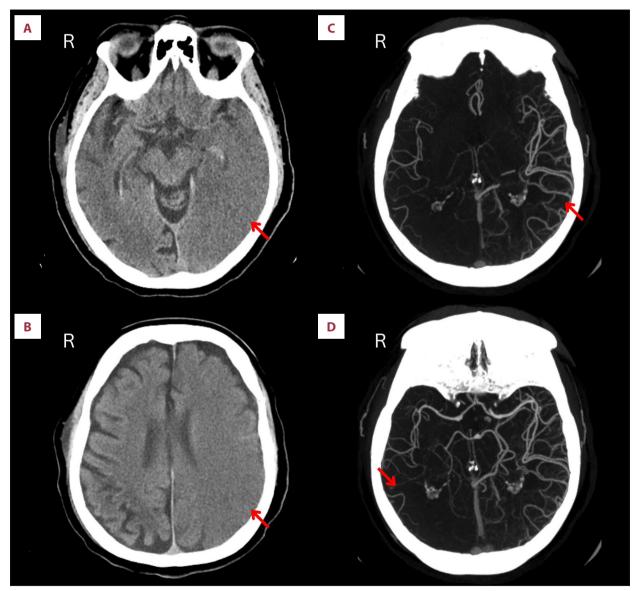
(A, B) Axial computed tomography brain scan showing mild hypodense acute ischemia zone throughout the left cerebral hemisphere, except the basal nuclei. (C, D) Angiography maximum intensity projection revealing more pronounced vasodilated cortical branches in the left middle cerebral artery than the right side with no conclusive data for lumen narrowing, double lumen fillings or pathological expansions.
